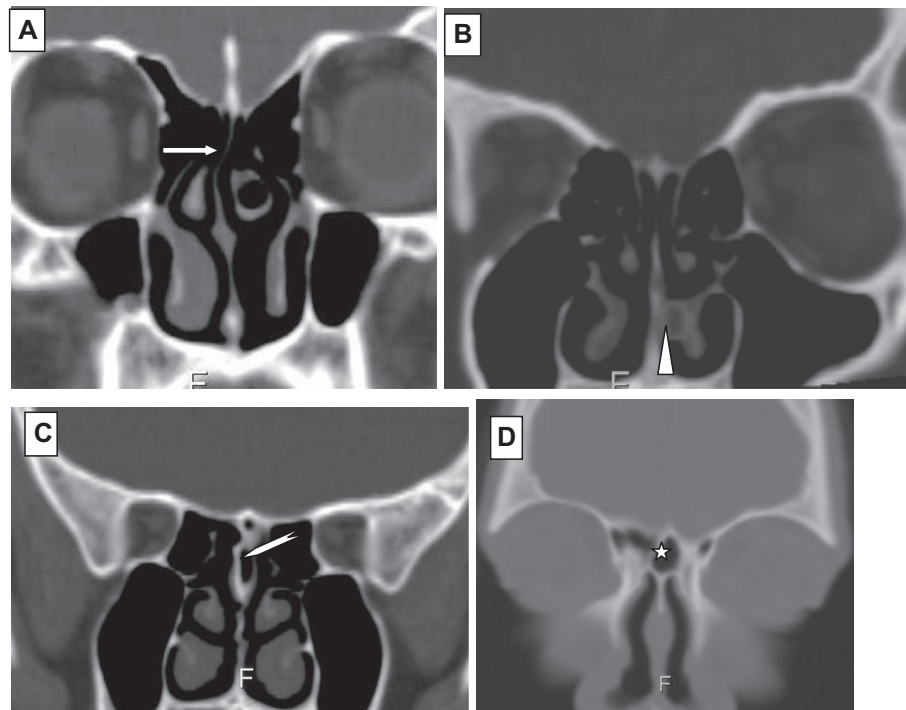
Coronal CT images showing (A) nasal septum deviation (arrow), (B) nasal septum spur fused with left inferior turbinate (arrow head), (C) pneumatisation of nasal septum (chevron) and (D) pneumatisation of crista galli.
